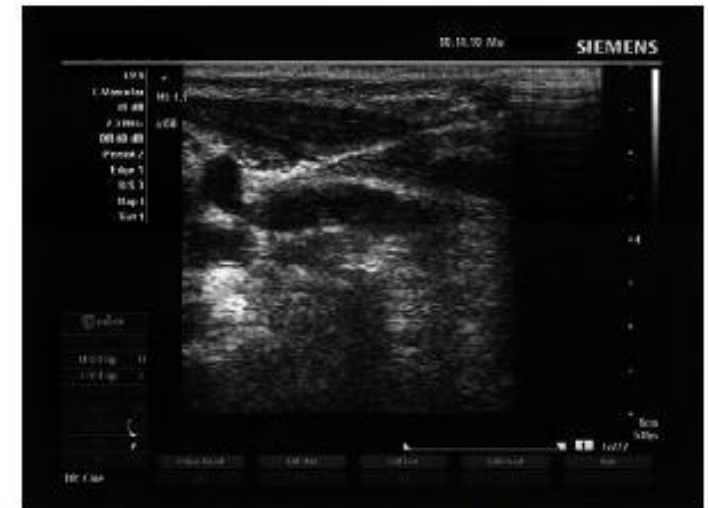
Ultrasound image of the right internal jugular vein shown in oblique orientation with the needle in long axis, and needle tip indenting the internal jugular vein just before puncture.
